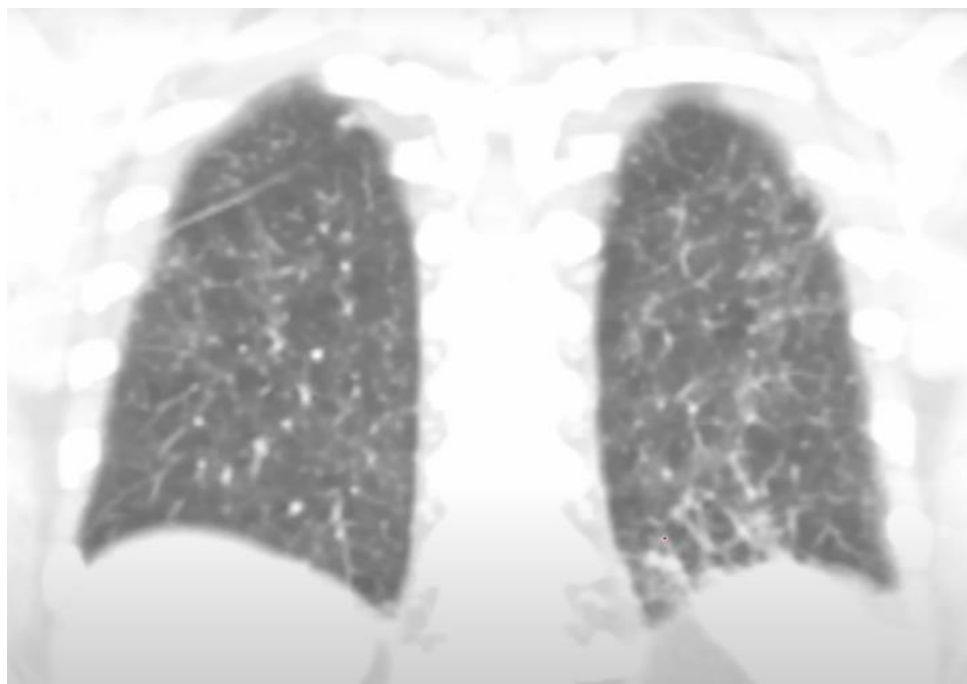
Coronal view of Computed Tomography (CT) of the chest, revealing diffuse bilateral tree-in-bud and micronodular opacities.
